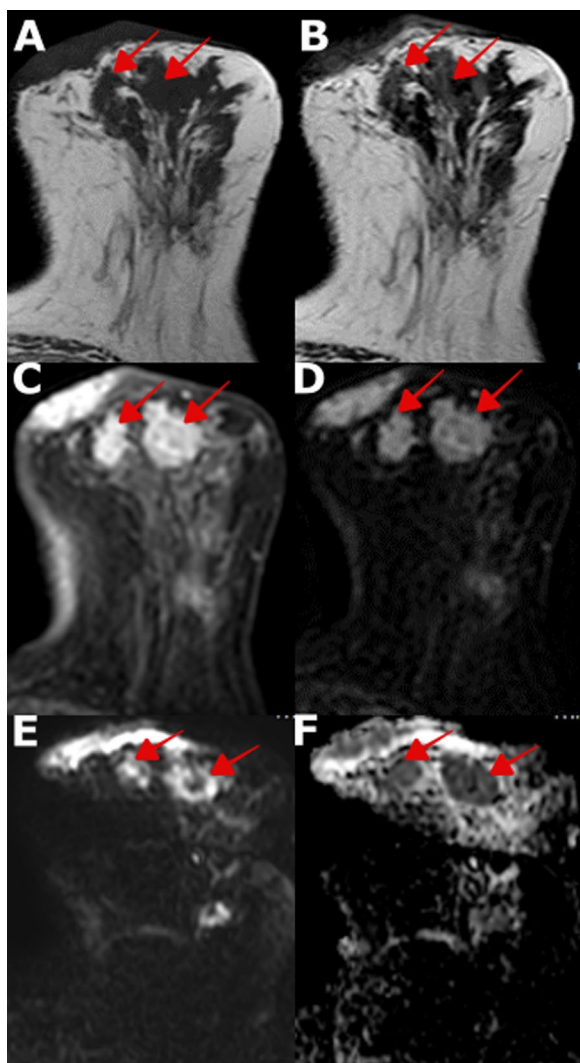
Female patient aged 67 years old complaining of a left breast lump. She had a family history of breast cancer (mother), and she had not received hormonal contraception before. MRI revealed: A & B Pre-contrast T1- and T2-weighted axial image showing: Multicentric masses with irregular shape and margin associated with thickened overlying skin at the left breast’s upper outer quadrant (UOQ). C & D Post-contrast dynamic and subtraction axial images showing: heterogeneously enhancing masses with thickened enhanced overlying skin as well as clumped segmental non-mass enhancement at the UOQ of the left breast. D & E DWI of the lesion shows high signal intensity and low signal in ADC map with mean lesion ADC value measured at largest lesion = 0.79×10^{-3} mm/sec and perilesional ADC = 1.4×10^{-3} mm/s. Pathology proved to be Grade II invasive duct carcinoma—Luminal A subtype—Ki-60%
